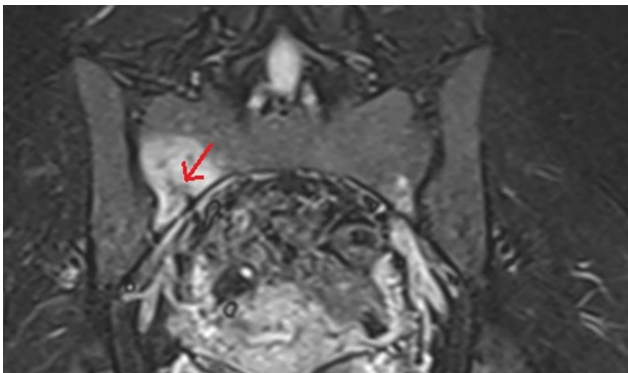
Hip magnetic resonance imaging (patient A). Imaging demonstrates a unilateral sacral ala stress fracture pattern with surrounding marrow edema, best appreciated on fluid-sensitive sequences. The arrow indicates bone marrow edema in the sacral ala with a visible fracture line.
